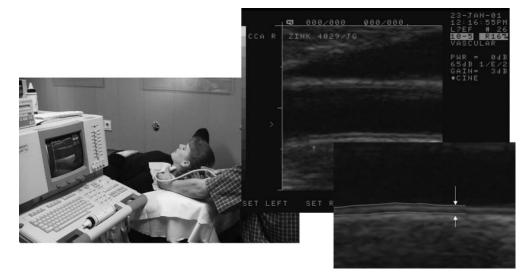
Carotid ultrasonographer capturing images of the common carotid artery. The frame in the foreground shows the edges of far-wall carotid intima-media thickness. Courtesy of Academic Medical Center, Amsterdam, The Netherlands.
